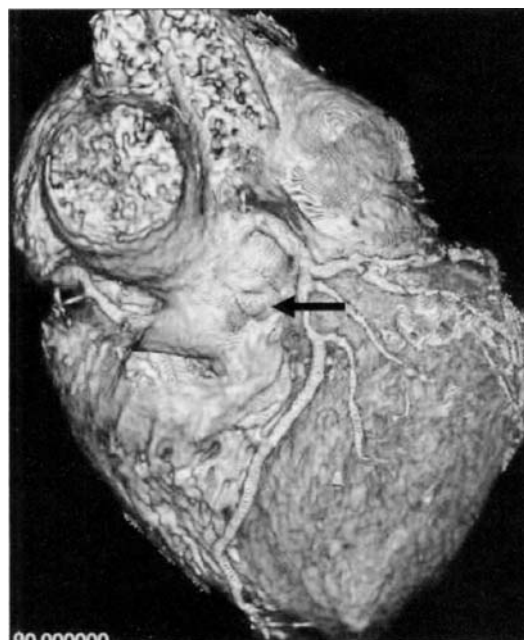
Whole heart coronary magnetic resonance imaging reconstruction in a patient with a proximal left anterior descending stenosis. Courtesy of Dr. Hajima Sukama.
